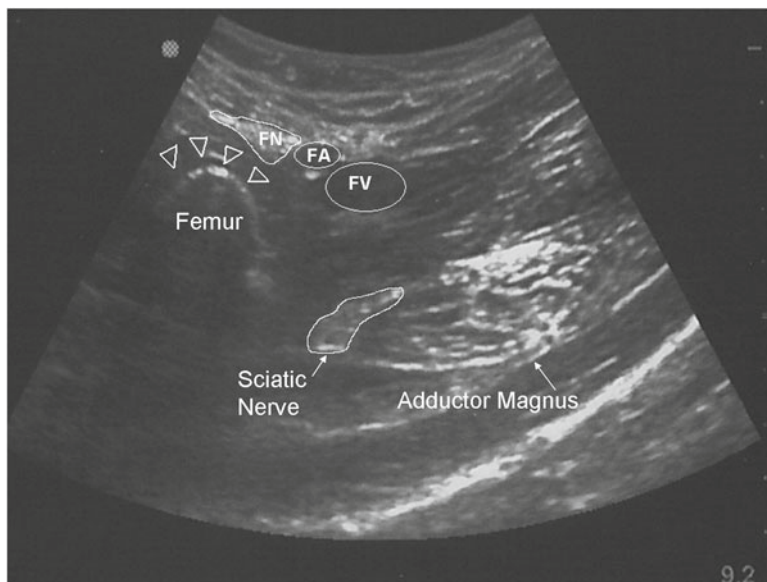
Ultrasound-guided anterior-medial approach. The femur is marked by four *arrow heads*, while the femoral nerve and vessels are *outlined superficially*: nerve (FN), artery (FA), and vein (FV). The sciatic nerve is identified and outlined medial and dorsal to the femur and lateral to the adductor magnus (*left is lateral and right is medial*)
